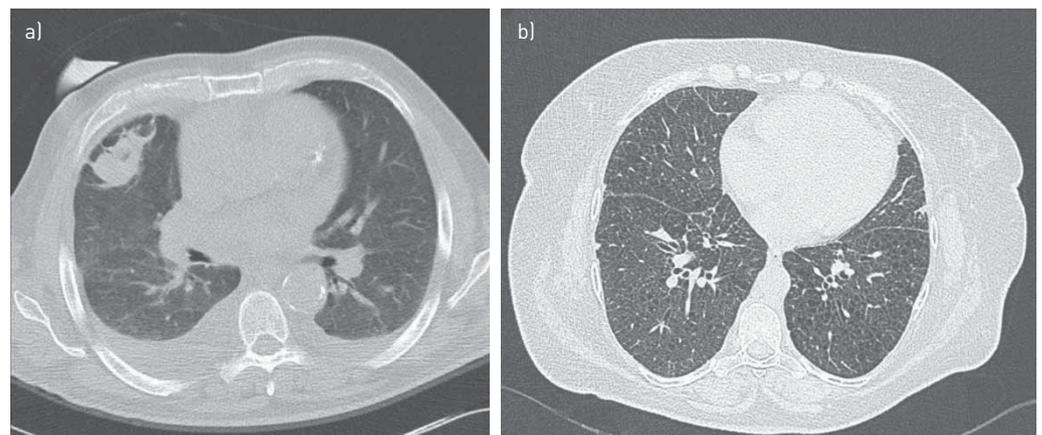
Radiology assessment of pulmonary amyloidosis. a) Computed tomography (CT) scan of the chest of a patient with nodular pulmonary amyloidosis; b) diffuse interstitial pulmonary amyloidosis in a patient with light-chain amyloidosis: high-resolution CT of the chest shows diffuse subpleural septal thickening.
